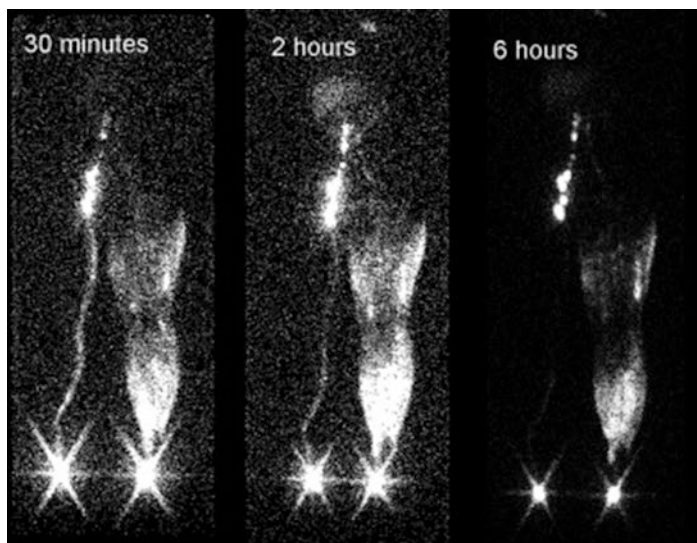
Lymphoscintigraphy showing left leg lymphedema. (Reproduced with permission from *Vascular and Endovascular Surgery A Comprehensive Review* ninth ed. Ch 56)
